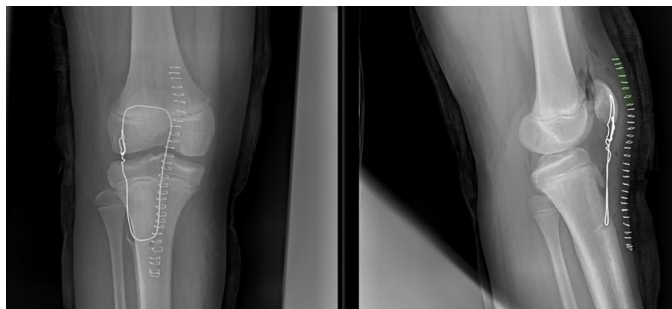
Postoperative radiographs showing decreased tendon length and return of patella to its anatomical site
